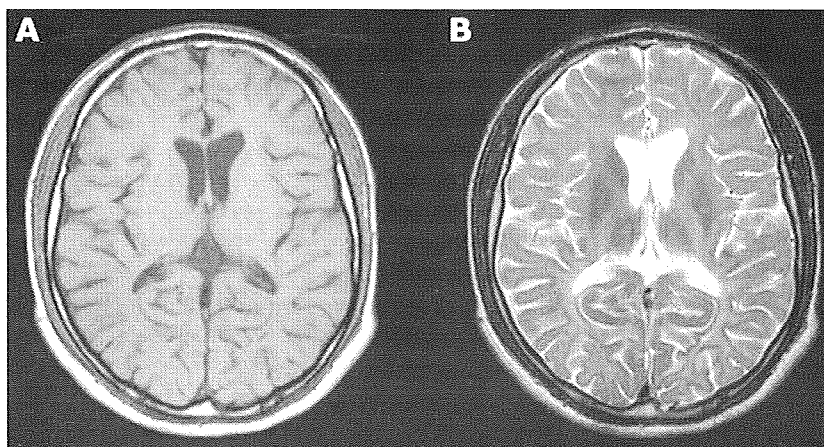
Magnetic resonance imaging (MRI) at 26 year-old patient shows disappearance of contrast between cortex and white matter (A) on a T1-weighted image. T2-weighted image shows the incompleteness of myelination in the white matter (B).
